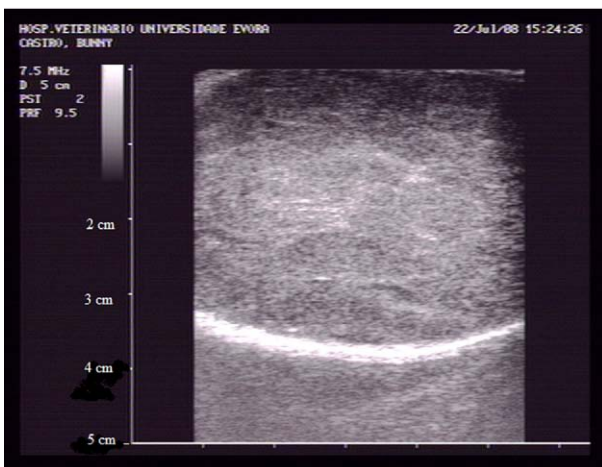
Ultrasonographic image of left testicle with mixed echotexture.
